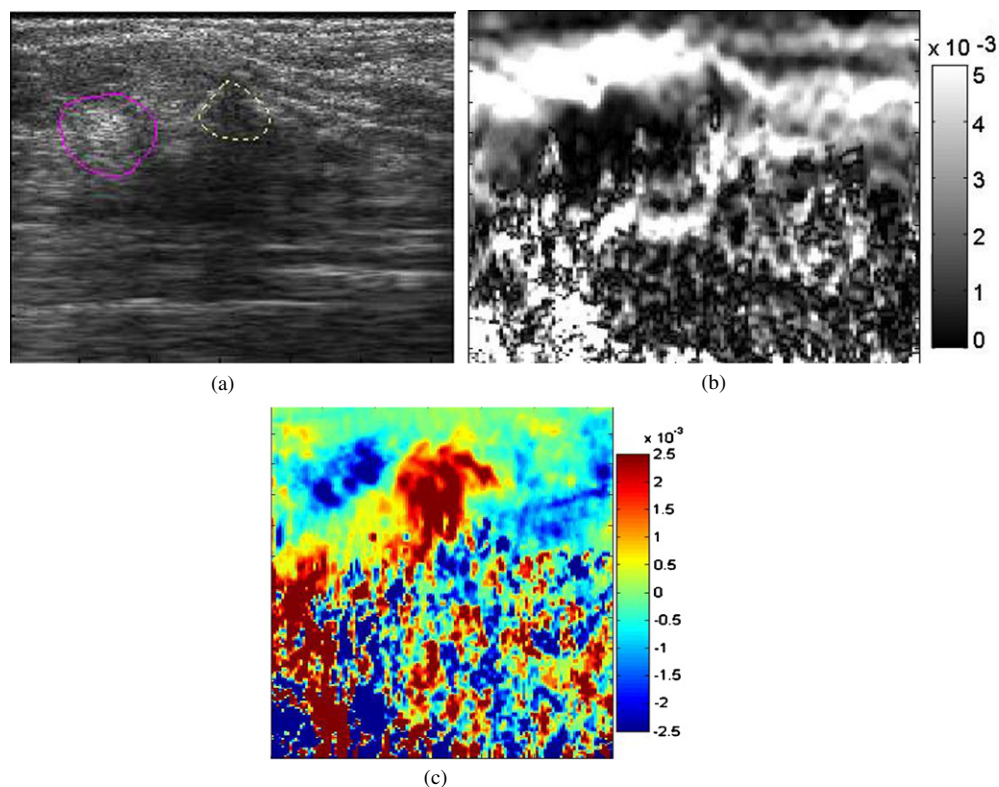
An example that demonstrates the ability of the axial-shear strain elastogram (right), to help locate the lesion in the sonogram (left), along with the axial strain elastogram (center). One observer's outline of a perceived tumor in the sonogram by looking at the sonogram alone (---) and in conjunction with elastograms (— magenta) is also shown.
